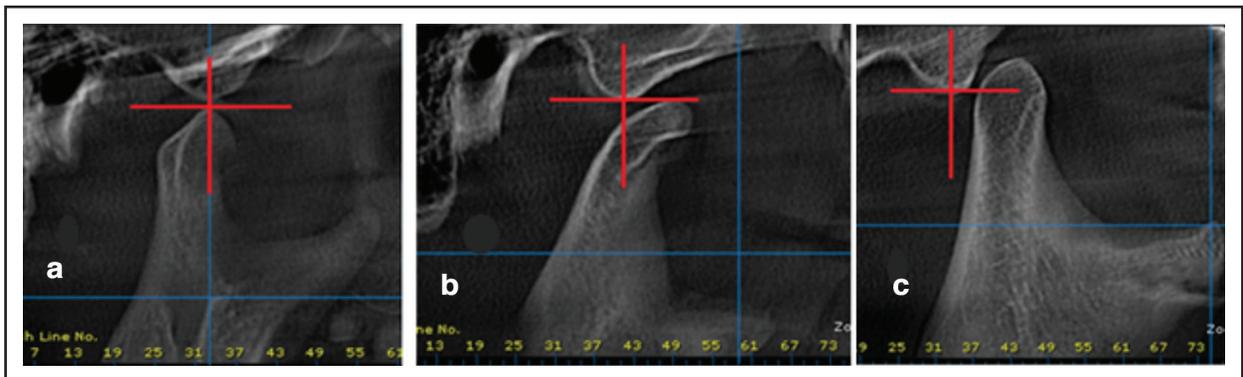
Sagittal CBCT cuts showing types of CP for different patients : a) Type 3: The condyle is directly below the eminence(subluxation), b) Type 4: Dislocated joint where the condyle is anterior and at the same level to the eminence, and c) Type 5: Dislocated joint in which, the condyle is anterior and superior to the eminence.
